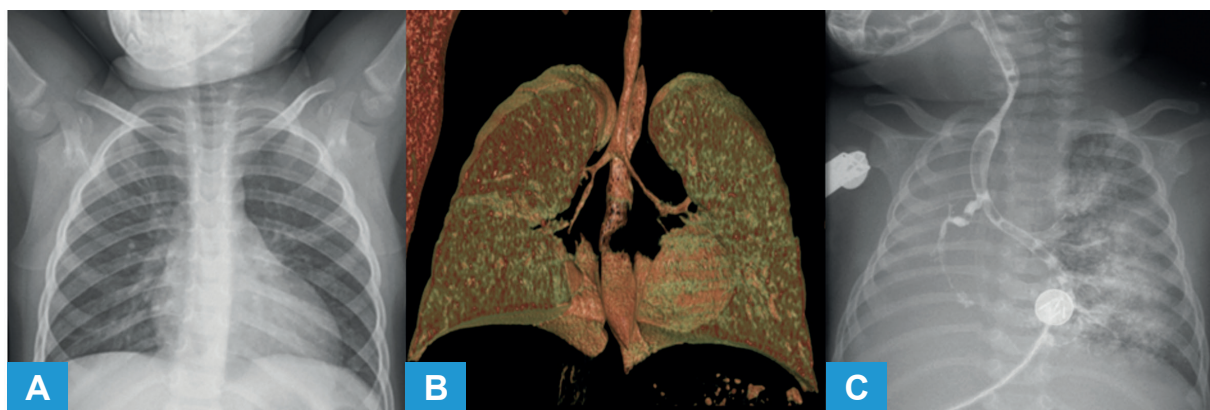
3-year-old baby with noisy breathing: (A) chest X-ray demonstrates that the distal part of the trachea is not clearly visible; (B) CT scan reconstruction showing the tracheal stenosis but also narrow main bronchi with the right especially narrow; (C) tracheobronchogram done with water soluble contrast medium demonstrates tracheal narrowing just below ETT. The right main bronchus is also narrow with absent RUL and RML bronchus.
